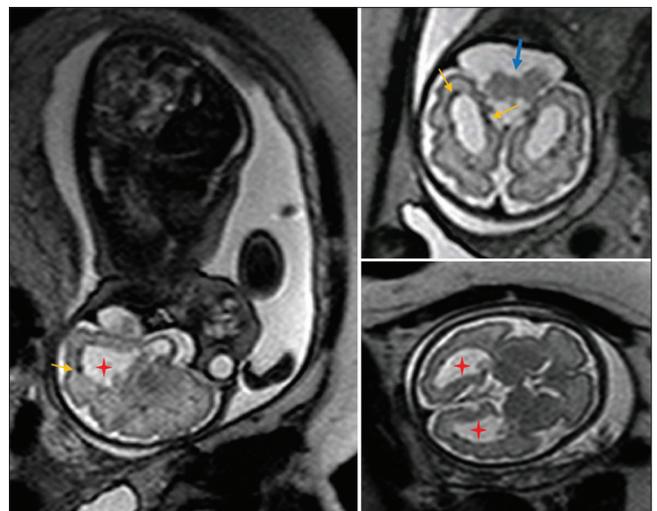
Fetal magnetic resonance imaging at 32w5d exhibiting hydrocephaly (red star), periventricular calcified foci (yellow arrow), and cerebellar vermis hypoplasia (blue arrow)
